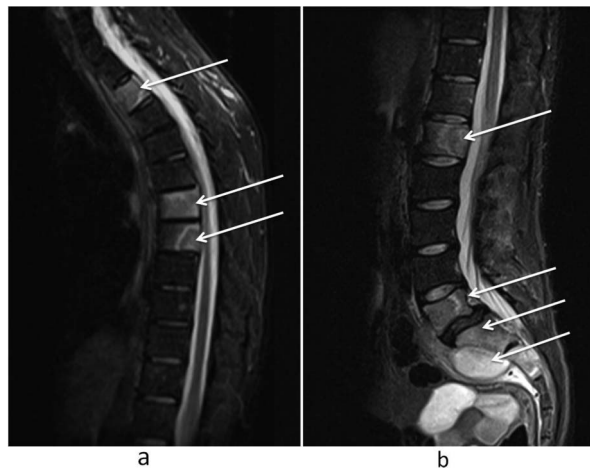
Sagittal MRI view of (A) thoraco-lumbar spine, (B) lumbo-sacral spine, demonstrating contiguous and non-contiguous spinal lesions as well as a 5.8×3.7 cm presacral abscess (white arrows).
